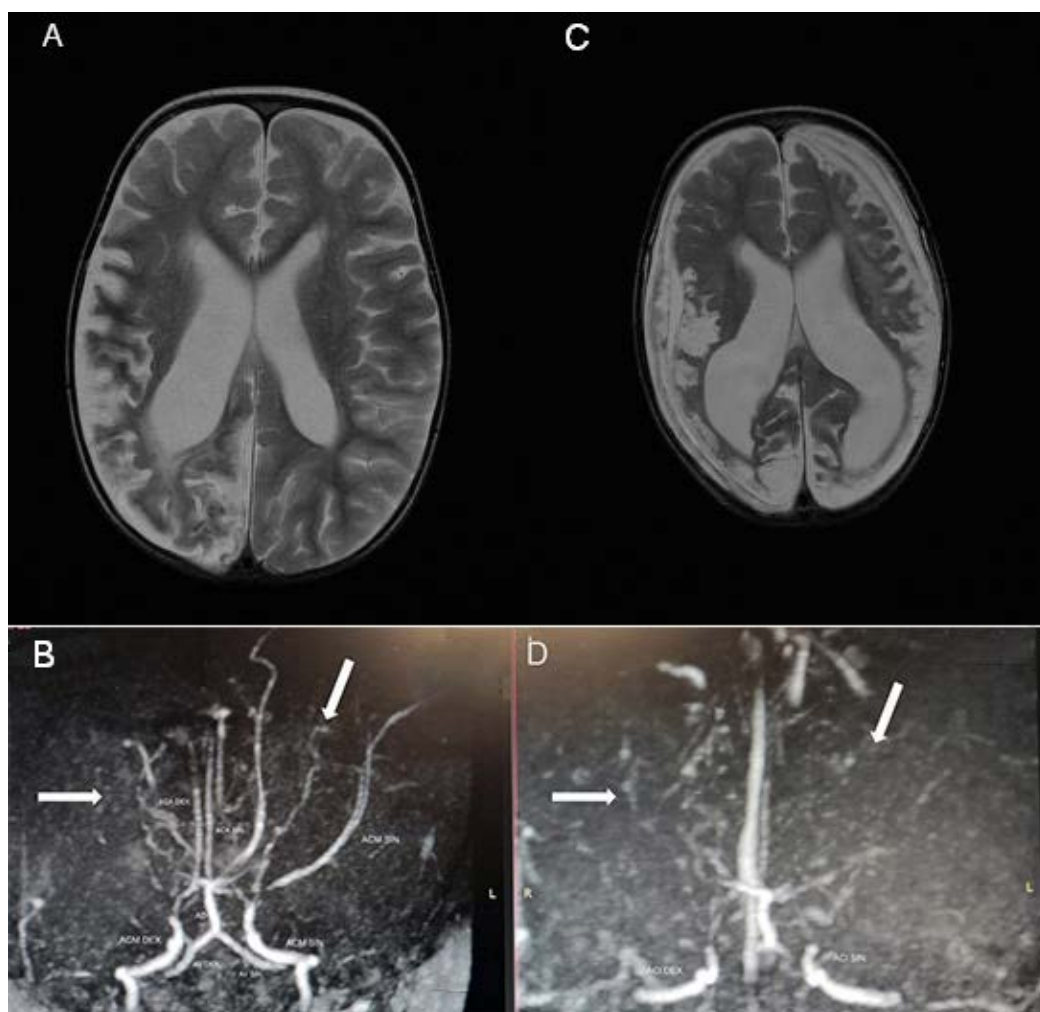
A. Right temporal and partial occipital lobe atrophy with increased signal intensity in the cortex, and the dilatation of the ventricular system; B. Absence of contrast flow in the right middle cerebral artery (MCA) with the bilateral abnormal collateral flow and bilateral shadows (arrows) on the same scan level at the basal ganglia region consistent with magnetic resonance imaging Moyamoya stage 2; C. Bilateral chronic subdural hematomas with sediment in the posterior portions of hematomas on the left side and more pronounced both brain atrophy and ventricular dilatation; D. Absent flow in both MCAs and flow reduction in both anterior cerebral arteries with the significantly less prominent collateral flow (arrows) consistent with advanced magnetic resonance imaging Moyamoya stage 3.
